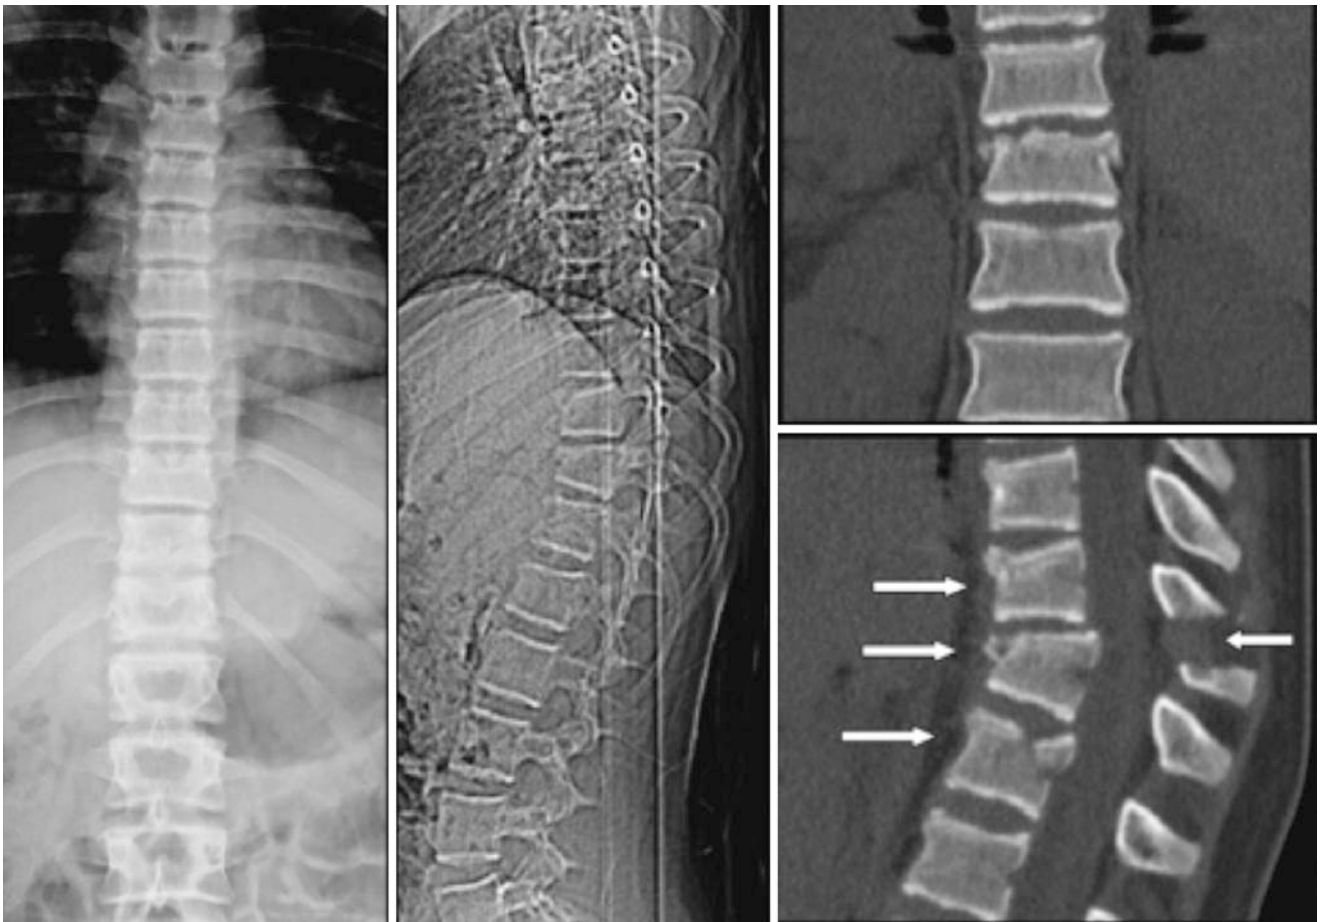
AP and lateral radiographs, and sagittal and coronal CT scan demonstrating AO Magerl Type B distraction thoracolumbar fracture. (Copyright © 2011 Springer-Verlag, with permission [36])
